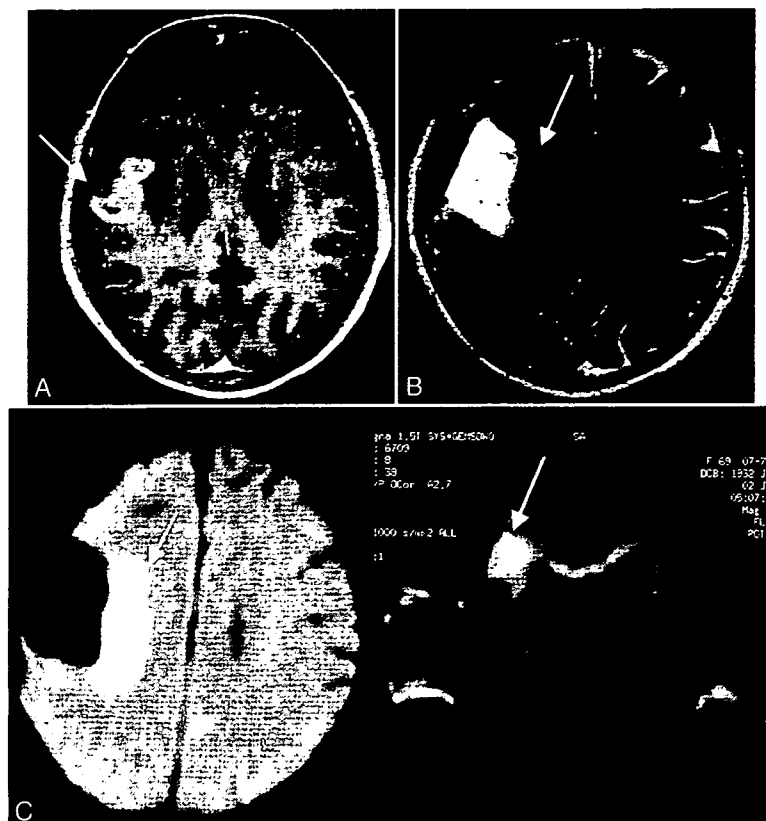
Case 6. Images obtained in a 69-year-old woman with a right frontoparietal GBM. A: Preoperative axial Gd-enhanced T₁-weighted MR image demonstrating an irregularly enhanced mass lesion in the opercular region around the central sulcus (arrow). B: Postoperative axial T₂-weighted MR image depicting total removal of the tumor and a new lesion of high intensity (arrow) beneath the resection cavity. C: Postoperative axial (left) and coronal (right) DW MR images revealing the new lesion (arrows) beneath the resection cavity with reduced diffusion probably involving the corticospinal tract.
